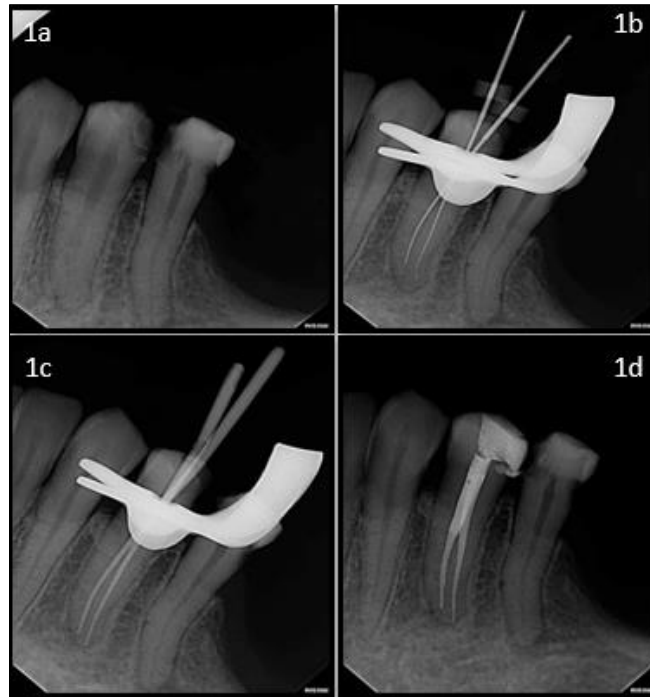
a- Pre-operative radiograph showing caries involving pulp
